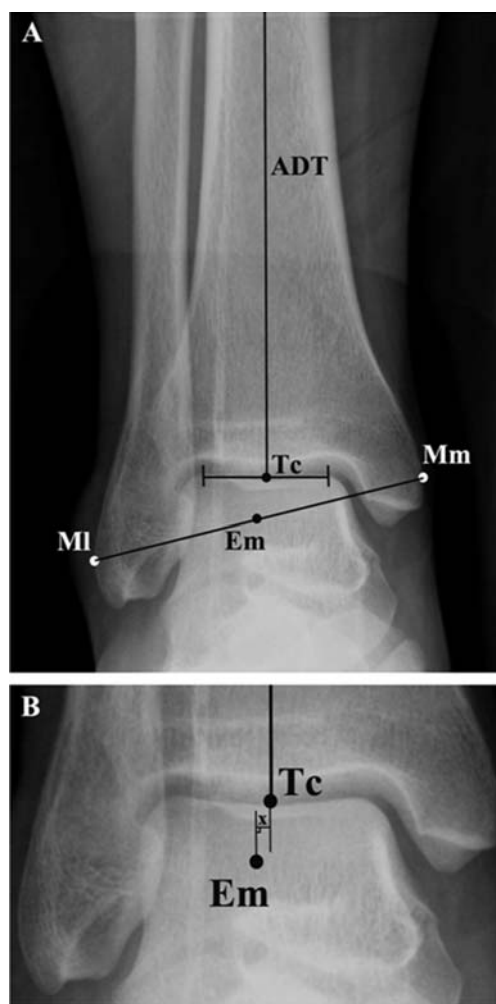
(A) The ankle radiograph shows the identification of the anatomical axis of the distal tibia (ADT), the center of the talus (Tc) and the extreme-midpoint [Em: the midpoint of a line connecting the most medial (Mm) and most lateral (Ml) aspects of the malleoli] (B) The zoom-in image demonstrates the measurement of the distance deviation (X)
